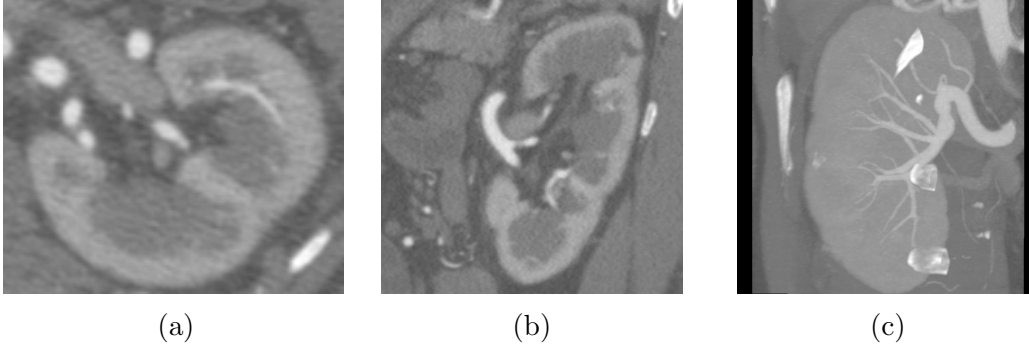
Volume of interest showing kidney in CT data: (a) and (b) one axial and sagittal slice, respectively. (c) MIP of image of VOI data.
